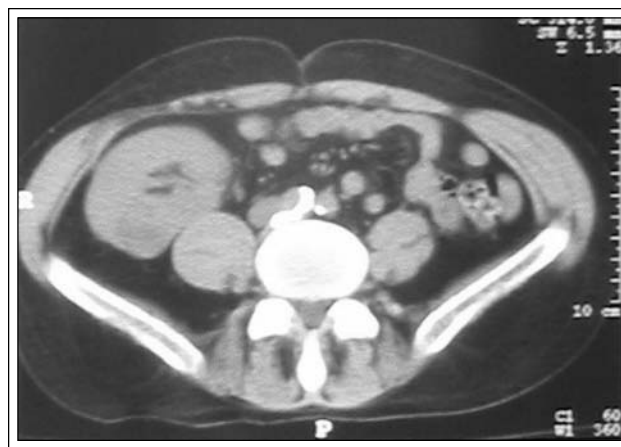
Noncontrast computed tomography of the pelvis confirming renal allograft tumor in posteromedial aspect.
